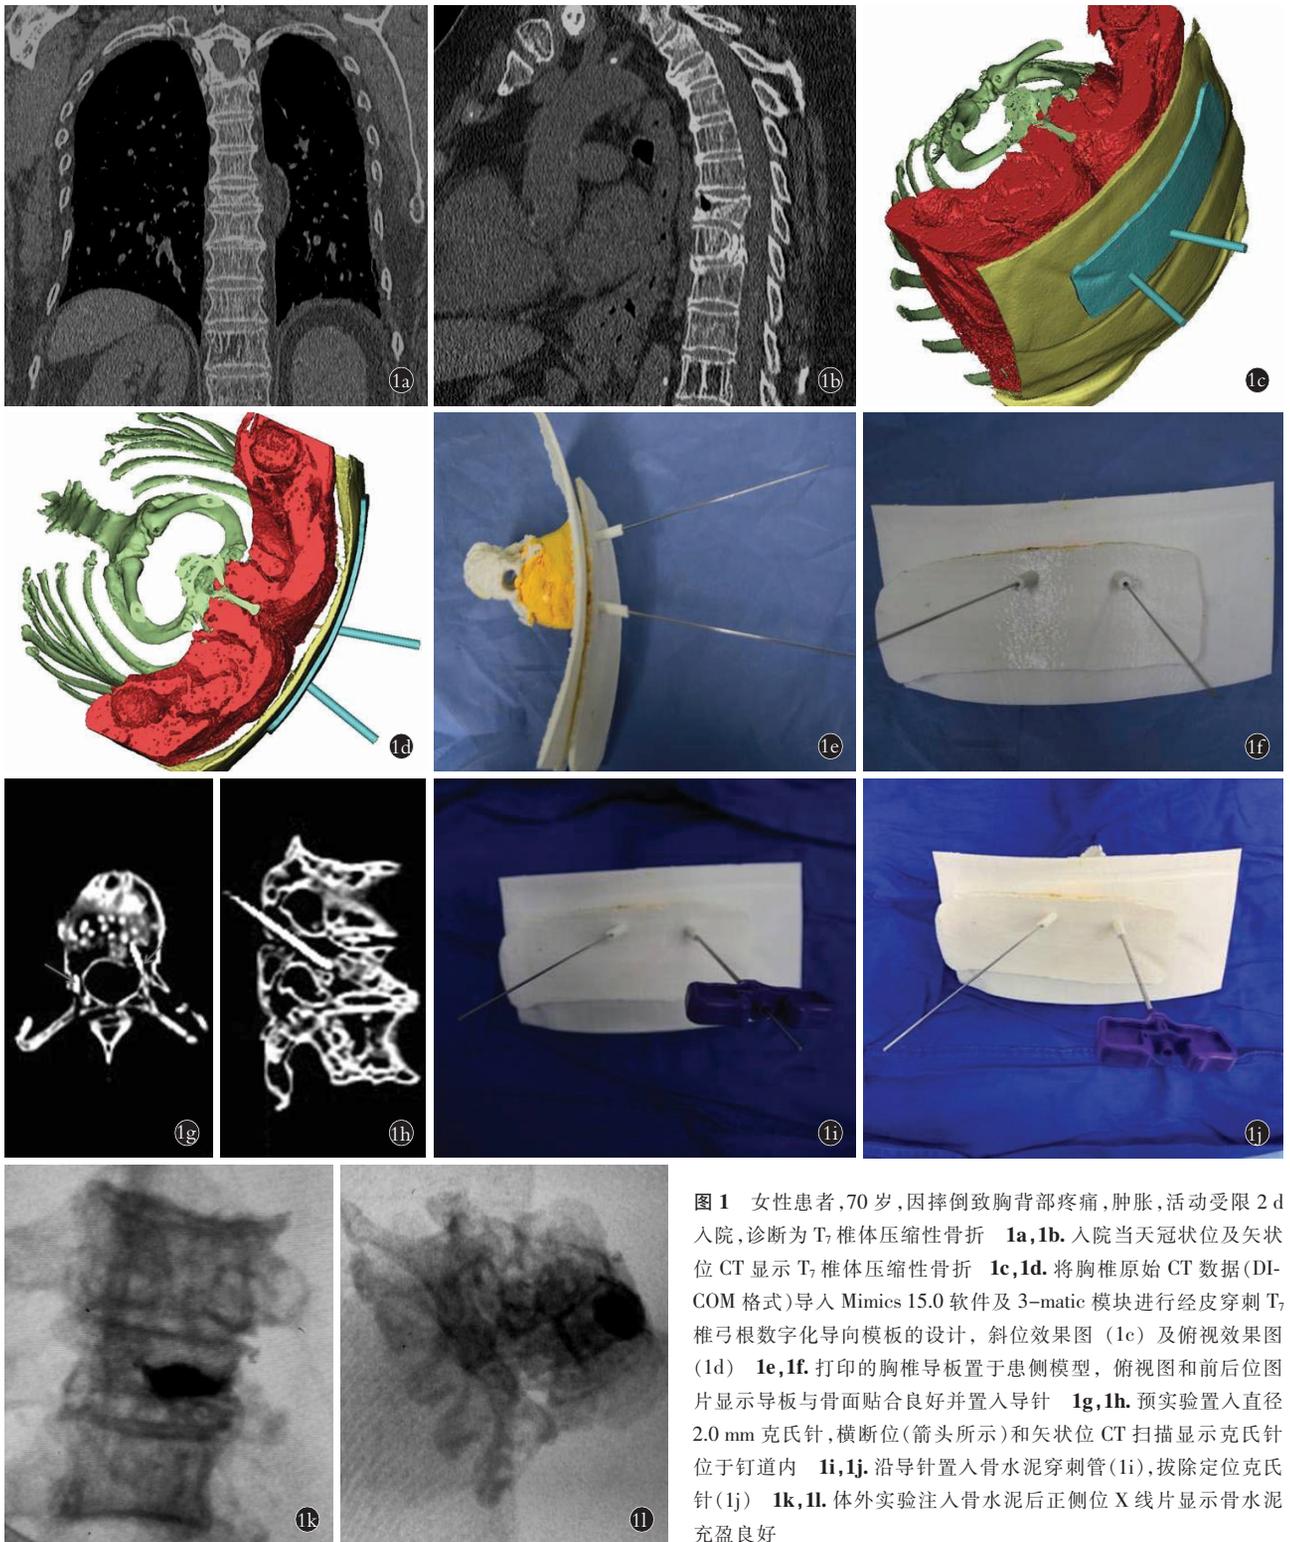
女性患者,70 岁,因摔倒致胸背部疼痛,肿胀,活动受限 2 d 入院,诊断为 T<sub>7</sub> 椎体压缩性骨折 1a,1b。入院当天冠状位及矢状位 CT 显示 T<sub>7</sub> 椎体压缩性骨折 1c,1d。将胸椎原始 CT 数据(DICOM 格式)导入 Mimics 15.0 软件及 3-matic 模块进行经皮穿刺 T<sub>7</sub> 椎弓根数字化导向模板的设计,斜位效果图(1c)及俯视效果图(1d) 1e,1f。打印的胸椎导板置于患侧模型,俯视图和前后位图片显示导板与骨面贴合良好并置入导针 1g,1h。预实验置入直径 2.0 mm 克氏针,横断位(箭头所示)和矢状位 CT 扫描显示克氏针位于钉道内 1i,1j。沿导针置入骨水泥穿刺管(1i),拔除定位克氏针(1j) 1k,1l。体外实验注入骨水泥后正侧位 X 线片显示骨水泥充盈良好
